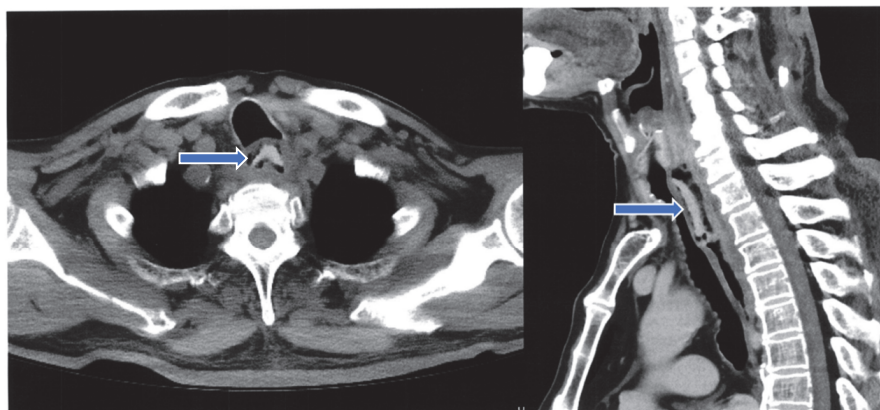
Chest CT revealed a FB (Arrow) in the cervical and upper thoracic esophagus without metallic components.
